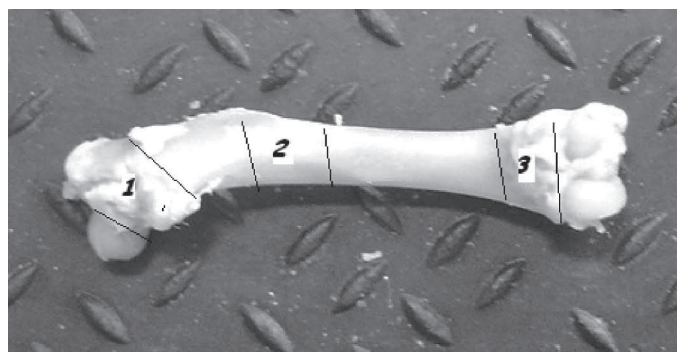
Demonstration of the areas of the femur that were examined using computed tomography
